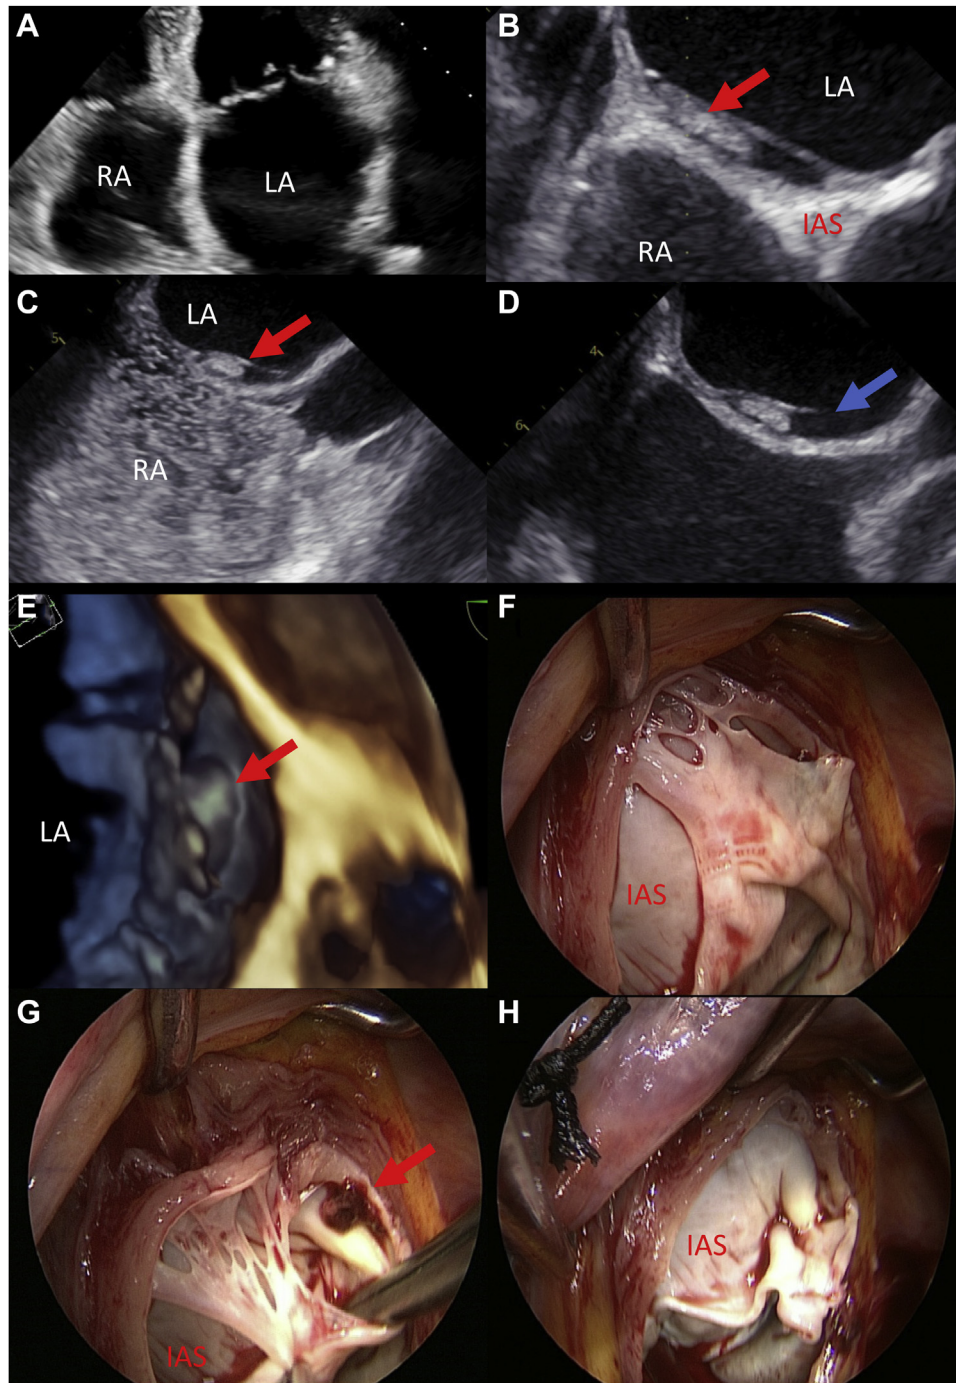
Thrombus in left atrial septal pouch prohibiting transseptal puncture for transcatheter mitral valve intervention. Transthoracic echocardiography showed no sign of a septal pouch (A). The red arrow indicates the thrombus in the left atrial septal pouch in transesophageal 2D echocardiography (B), 3D echocardiography (C), and intraoperative (E,G). The blue arrow shows the entry-connection of the pouch to the left atrium (D). Saline contrast study was negative (C), indicating the absence of a PFO. Accordingly, no PFO was found intraoperatively after removal of perforated membrane covering the interatrial septum (H). IAS, interatrial septum; LA, left atrium; PFO, patent foramen ovale; RA, right atrium.
